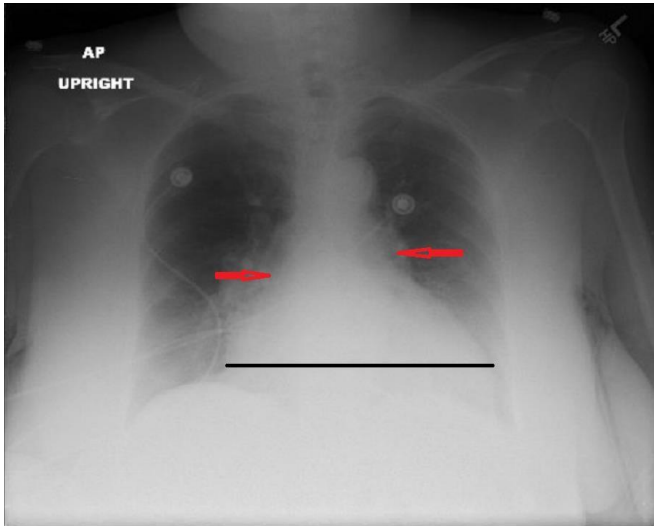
Chest X-ray on admission revealed cardiomegaly (horizontal black line) and pulmonary congestion (red arrow)
